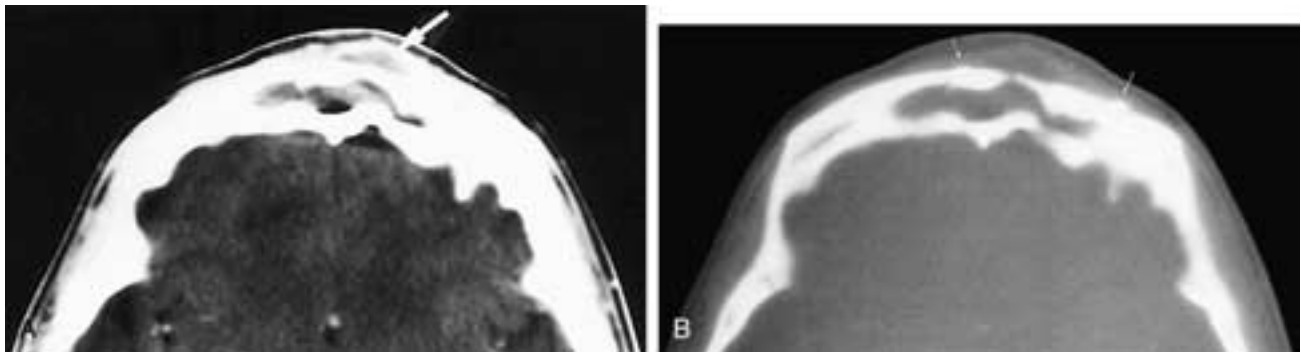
Axial CT scans at soft tissue (A) and bone (B) window settings show a patient who had a left osteoplastic flap. The small wire sutures stabilizing the flap can barely be seen in (B) (*small arrows*). There is erosion of the midanterior bone flap, and an abscess is present in the forehead (*arrow* in A). The fat used to obliterate the sinus is also dense, reflecting infection.
